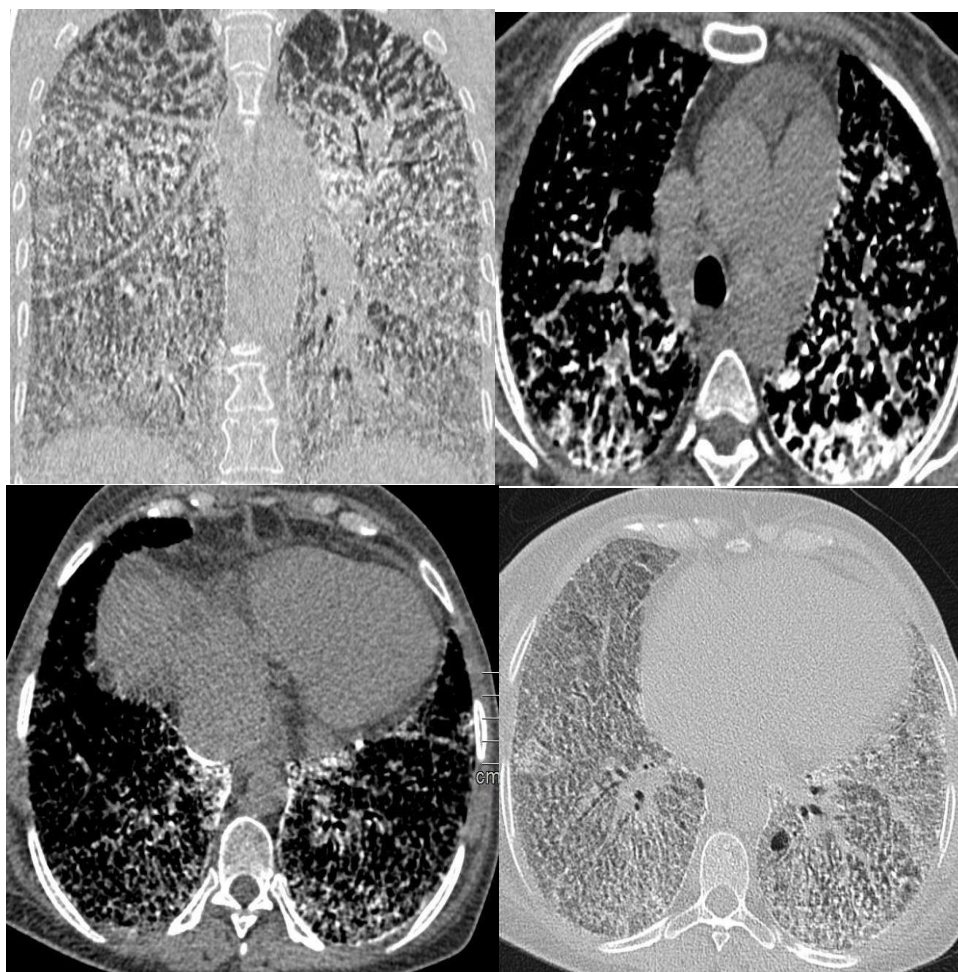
High resolution computed tomography (HRCT) of the chest revealing innumerable calcifications throughout the parenchyma, partially calcified para pleural and para mediastinal line, subpleural cystic changes and calcified interlobular septa
